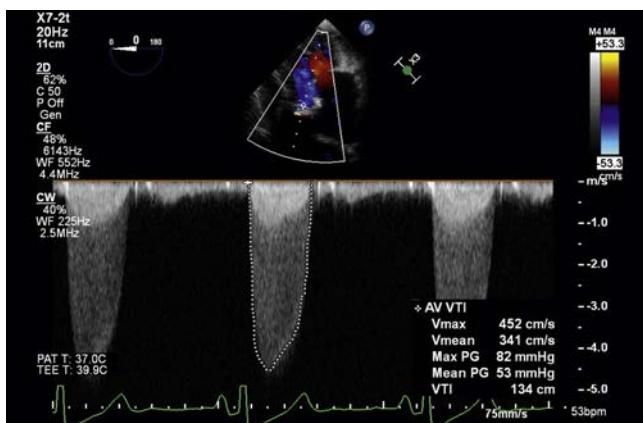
The transvalvular pressure gradient across a stenotic aortic valve is estimated using continuous wave Doppler in the transesophageal deep transgastric view. The peak gradient is derived from the peak velocity of the spectral Doppler signal using the simplified Bernoulli equation. The mean gradient is the average of the instantaneous peak gradients throughout systole and is obtained by tracing the Doppler envelope. The ultrasound system will automatically calculate the mean pressure gradient from the tracing. The measurements in this example are consistent with severe aortic stenosis.
